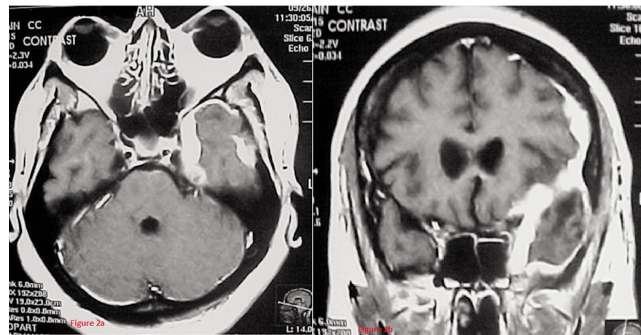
Postsurgical MRI after 6 months. Postcontrast axial (a) and coronal (b) images demonstrate residual enhancing meningeal nodularity, with decreased left temporal lobe edema and no midline shift.
